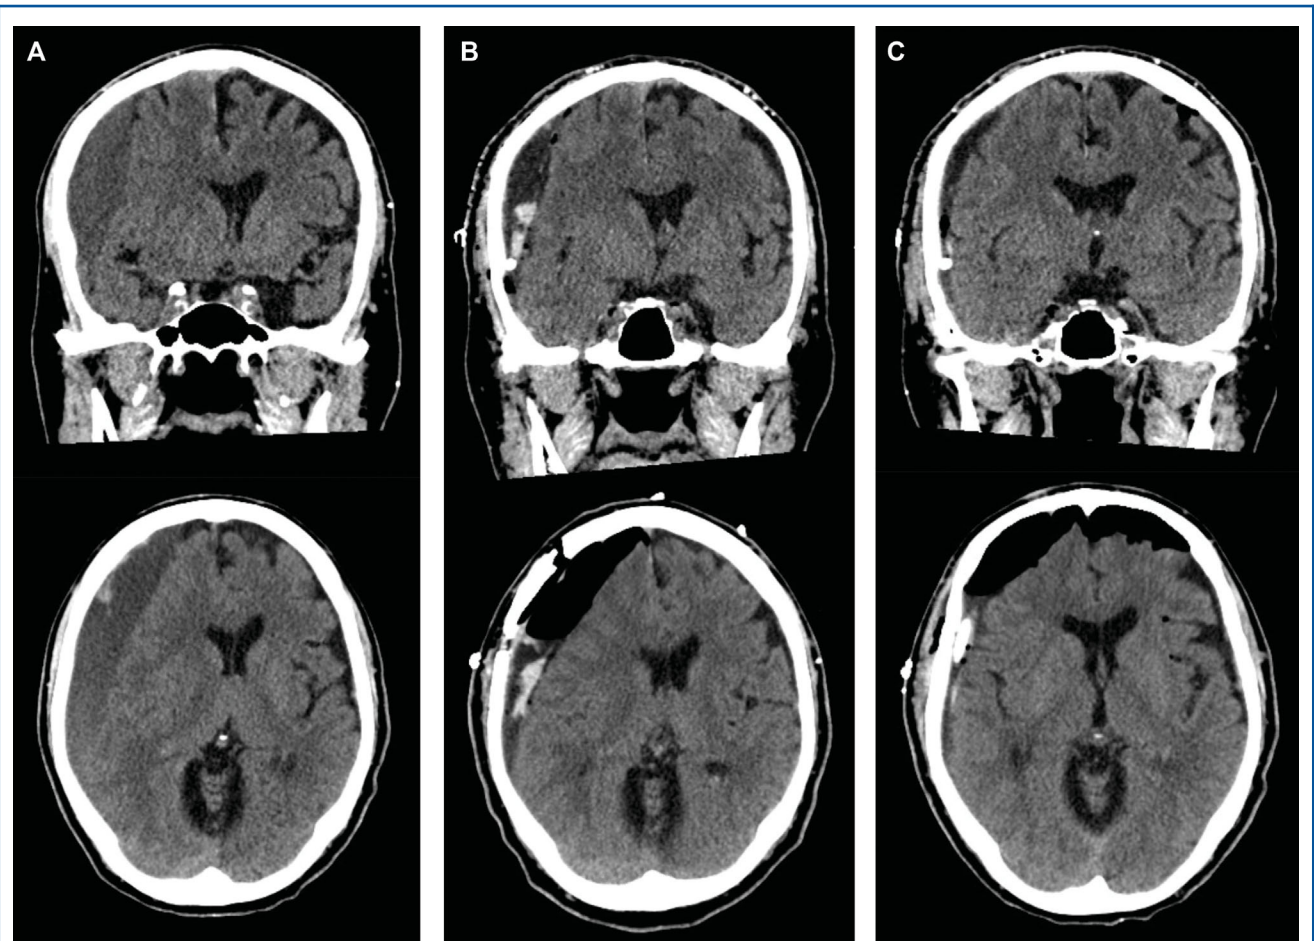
Axial and coronal head computed tomography. A, Preoperative imaging shows 25-mm-thick, mixed attenuating, extra-axial hemorrhage, causing 7 mm leftward midline shift. B, Immediate postoperative imaging shows pneumocephalus and mixed attenuating, extra-axial collection with persistent 7 mm leftward midline shift. C, Postoperative day 1 imaging shows decrease in extra-axial collection to 12 mm thick with trace midline shift.
